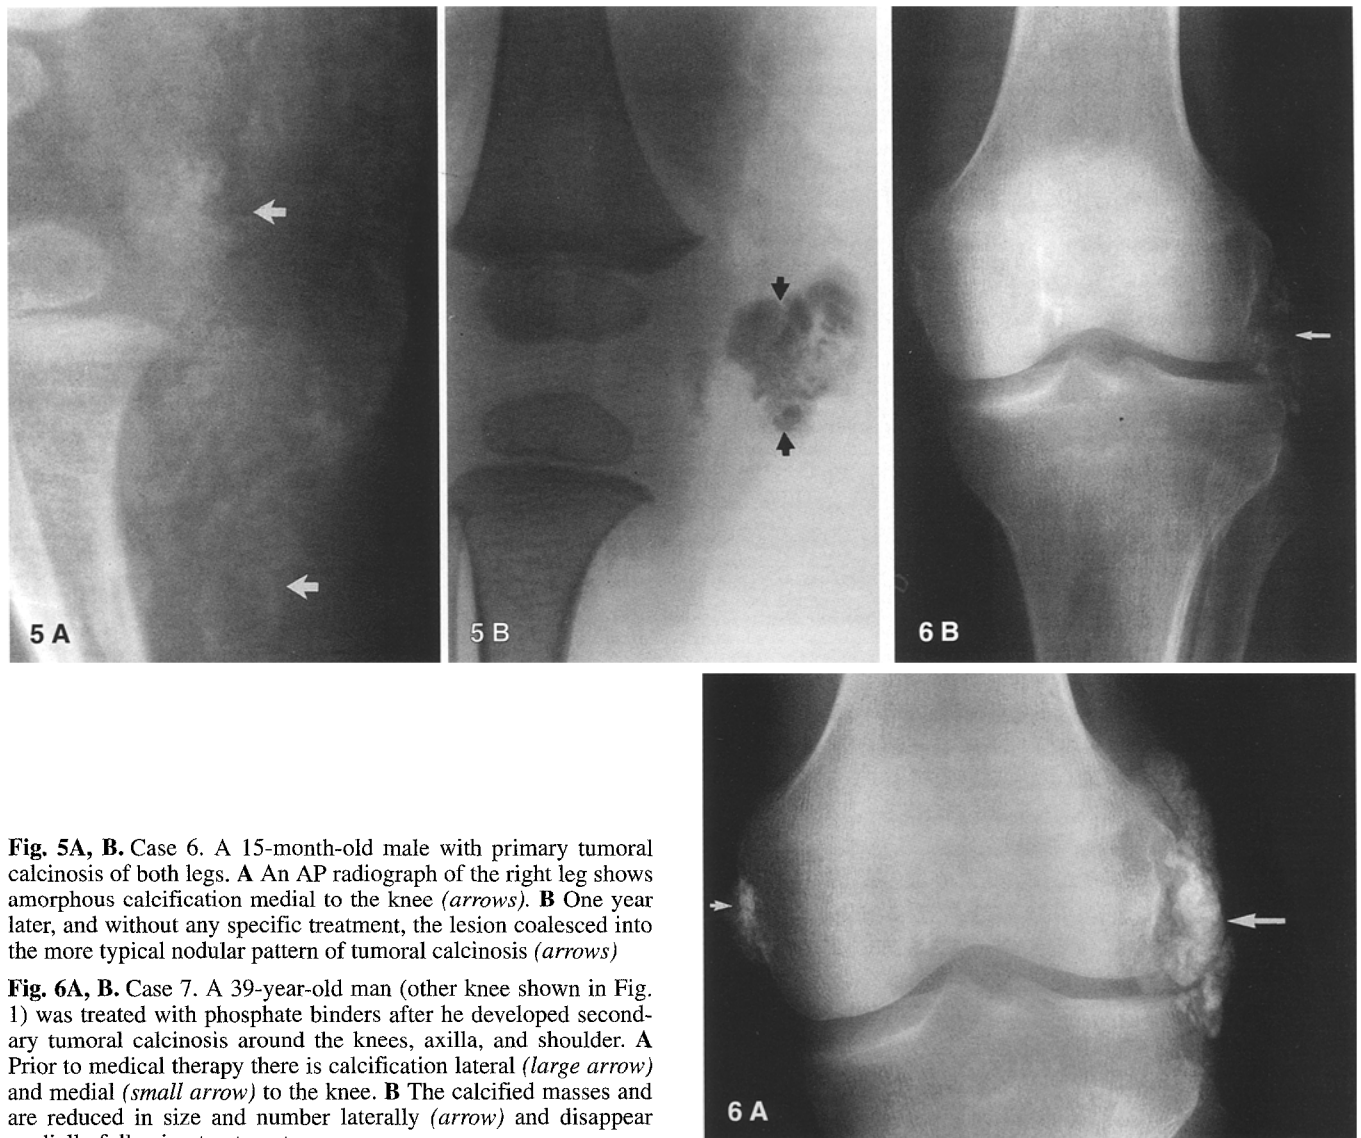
Case 6. A 15-month-old male with primary tumoral calcinosis of both legs. A An AP radiograph of the right leg shows amorphous calcification medial to the knee (*arrows*). B One year later, and without any specific treatment, the lesion coalesced into the more typical nodular pattern of tumoral calcinosis (*arrows*)
